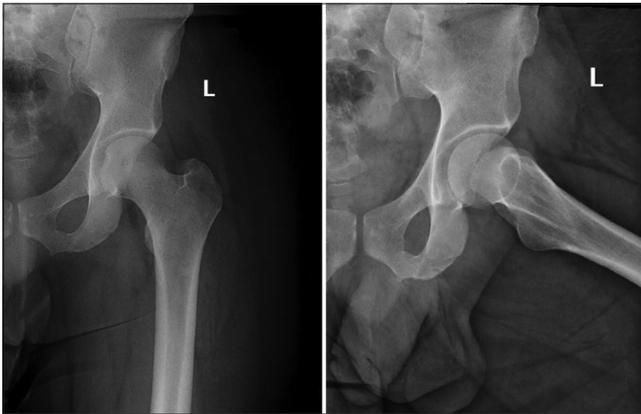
Pelvis and femur radiographs X-ray were normal.
